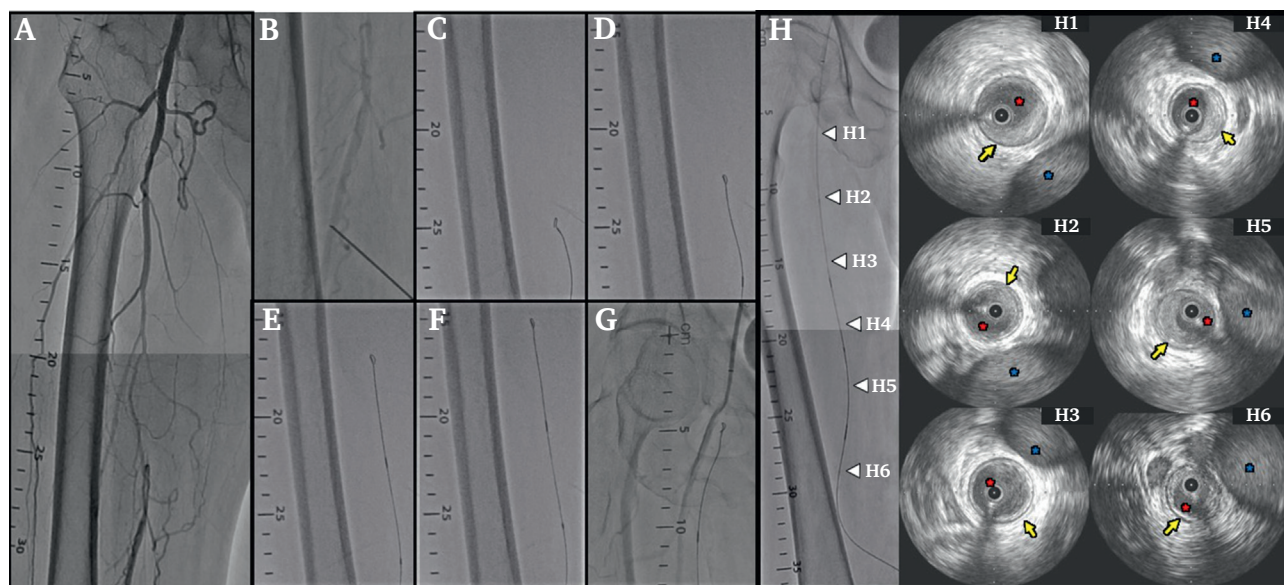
Crossing of the SFA CTO; narrow looped wire technique. Right SFA CTO (A). Distal SFA puncture was performed (B). A 0.018 inch guidewire was advanced into the CTO segment with the smallest loop (C–G), and IVUS findings show complete true lumen passage (H, red asterisk: true lumen, yellow arrow: media, and blue asterisk: femoral vein). CTO = chronic total occlusion; IVUS = intravascular ultrasound; SFA = superficial femoral artery.
